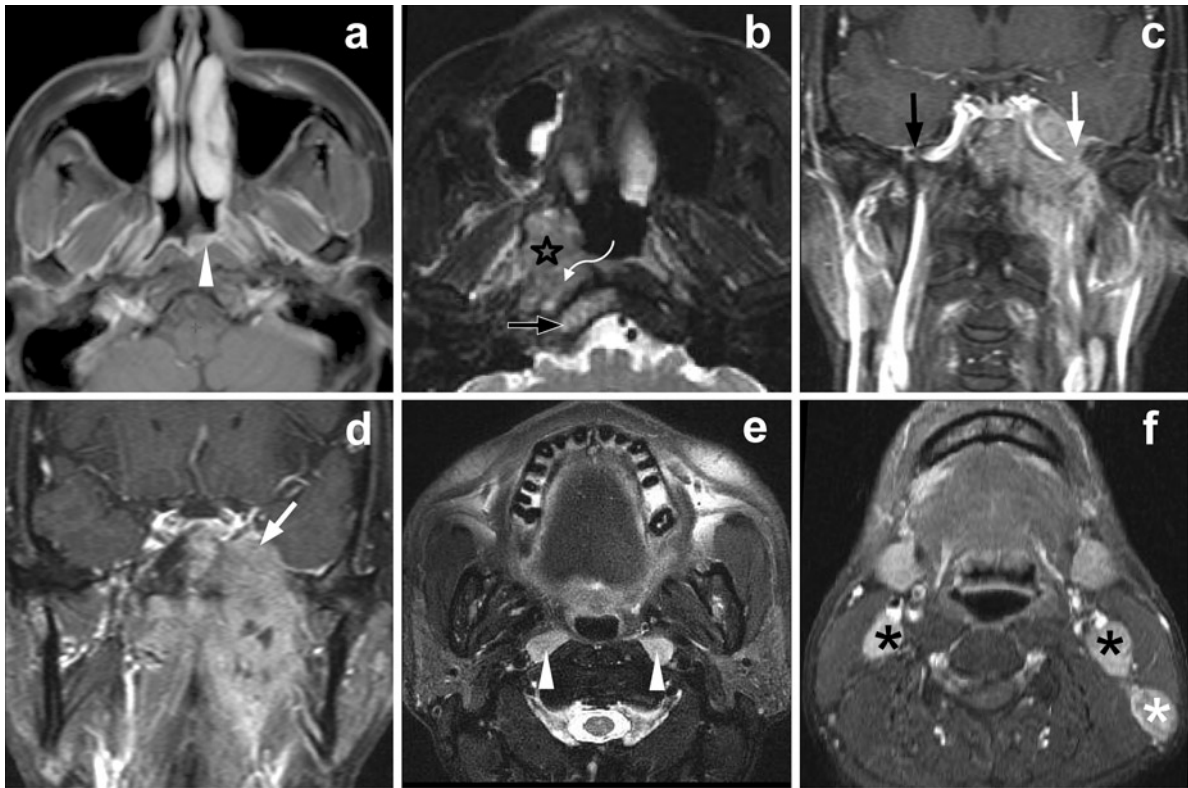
MRI showing different patterns of local and lymphatic involvement by nasopharyngeal carcinoma: (a) small primary tumor (white arrowhead); (b) extension into parapharyngeal space (star), prevertebral muscle (curved arrow), and clivus (black arrow); (c) the infiltrated foramen ovale (white arrow) as compared to the normal
